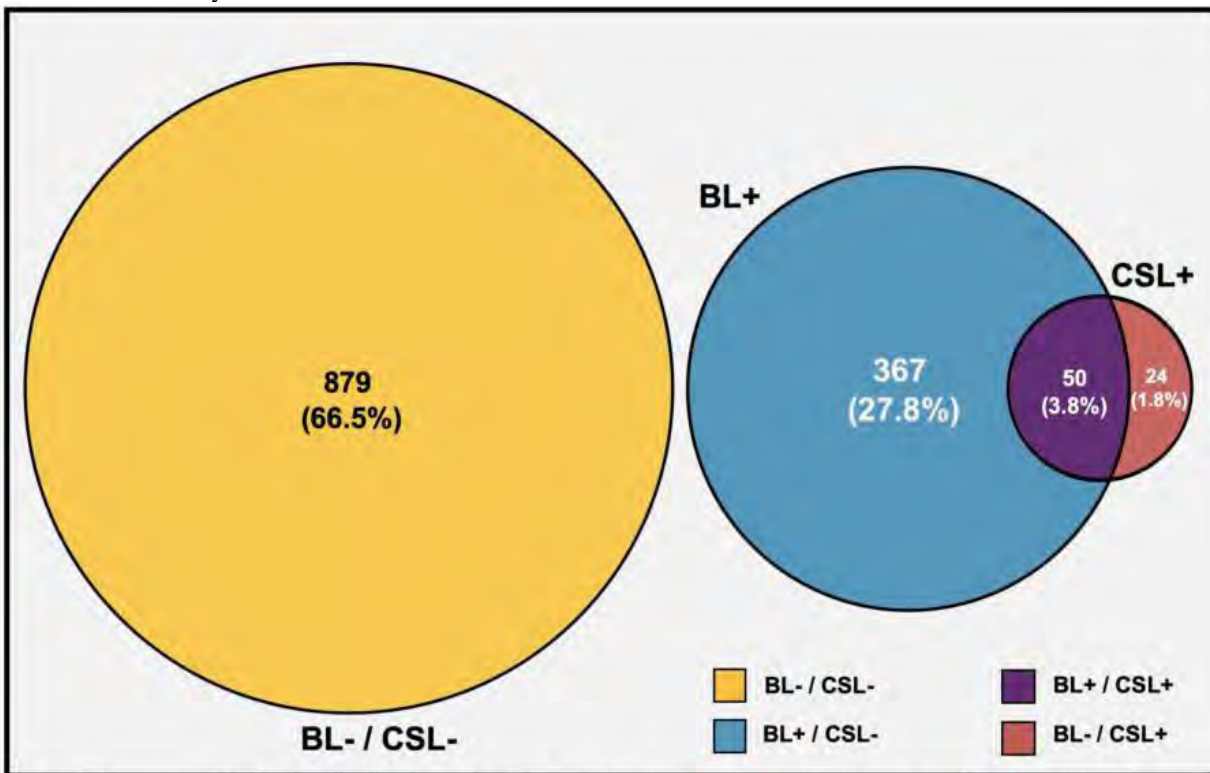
Frequency of MRI lesions in clinical stable pwMS. BL-: No new asymptomatic lesion on brain MRI. BL+: At least one new asymptomatic lesion on brain MRI. CSL-: No new asymptomatic lesion on cervical spinal cord MRI. CSL+: At least one new asymptomatic lesion on cervical spinal cord MRI.
